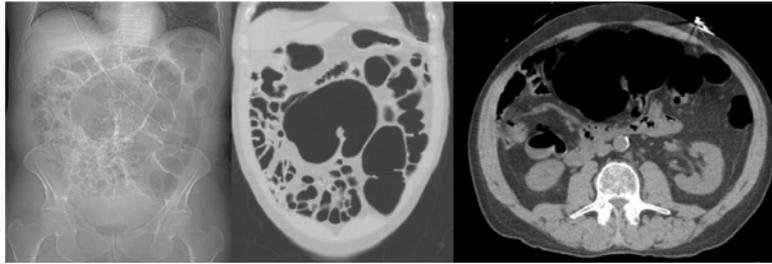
CT abdomen and pelvis showing midline cecum with volvulus.
